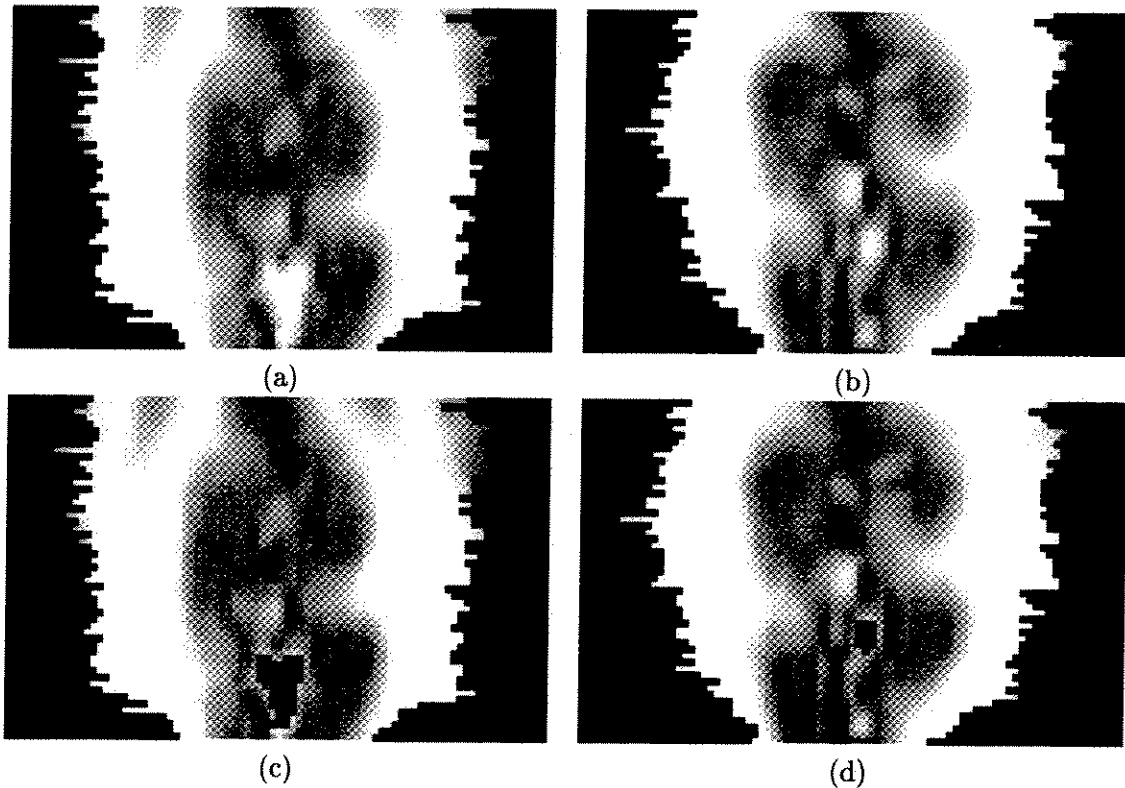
Dynamic programming algorithm used to track and mask out unwanted blood vessels. (a)-(b) The MR image with unwanted blood vessel. (c)-(d) The vessel is tracked and masked out through the use of dynamic programming.
